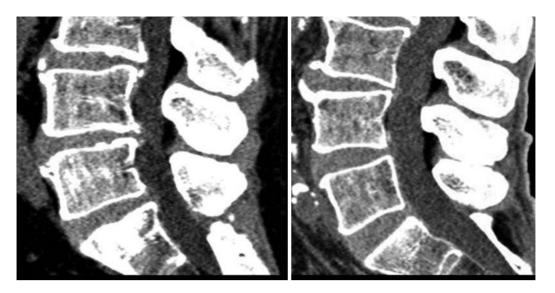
Sagittal reconstructions in an obese patient (*right image*) with a BMI of 54.2 kg/m^2 , and in a thin patient (*left image*) with a BMI of 21.5 kg/m^2 are shown. Automatic exposure-controlled acquisitions were obtained with tube voltage settings respectively of 140 and 120 kVp and with indexes of image quality expressed in effective mAs respectively of 350 and 280 mAs. The resultant CTDI_{vol} values were 33.8 and 9.8 mGy. Despite a five times higher dose, the image noise seen in the obese patient's image on the *right* is greater than that obtained from the thin patient on the *left*. These dose levels are lower than the mean reference values from surveys of CT scans of the lumbar spine
